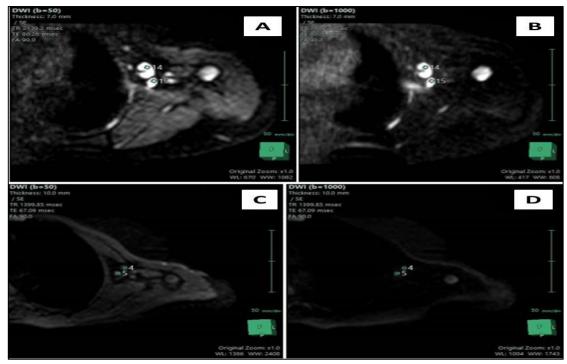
A-B) a case with DWI (b=50&b=1000) shows restricted left axillary LNs, C-D) a case with DWI (b=50&b=1000) show non-restricted left axillary LNs).
